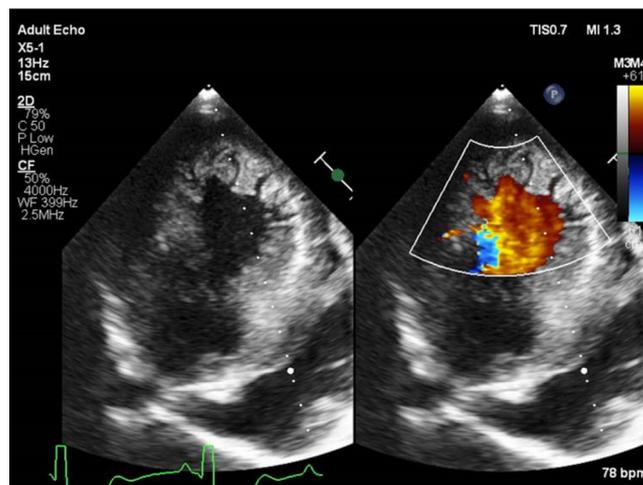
Transthoracic echocardiogram of a patient with severe LV hypertrophy secondary to aortic stenosis showing multiple deep crypts in the LV wall.
